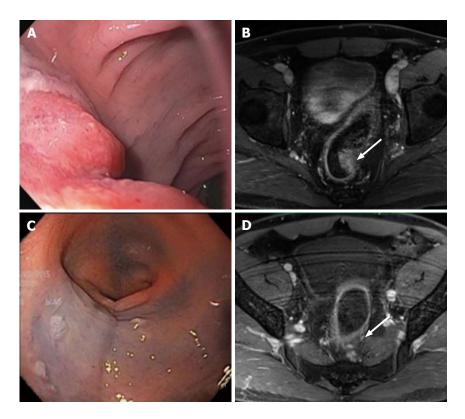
Complete clinical response. Evaluation of the rectal cancer prior to the initiation of neoadjuvant chemoradiation therapy by flexible sigmoidoscopy (A) and MRI (B, white arrow: Tumor). Evaluation of 7 wk after completion of neoadjuvant chemoradiation therapy showed no evidence of tumor by flexible sigmoidoscopy (C) and MRI (D, white arrow: Tumor). MRI: Magnetic resonance imaging.
